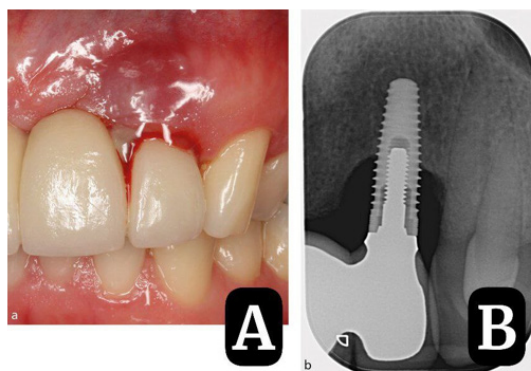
Clinical and radiographic features of peri-implantitis. (A): Clinical photograph showing inflammation, swelling and bleeding in the peri-implant soft tissues. (B): Radiographic image showing bone loss around the dental implant [26].
